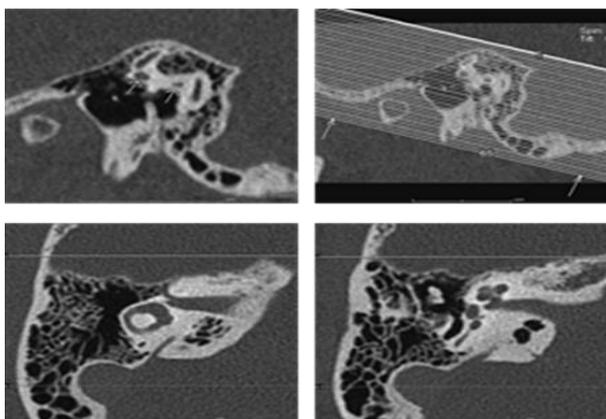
Creation of standard axial and coronal CT scan data of temporal bones
